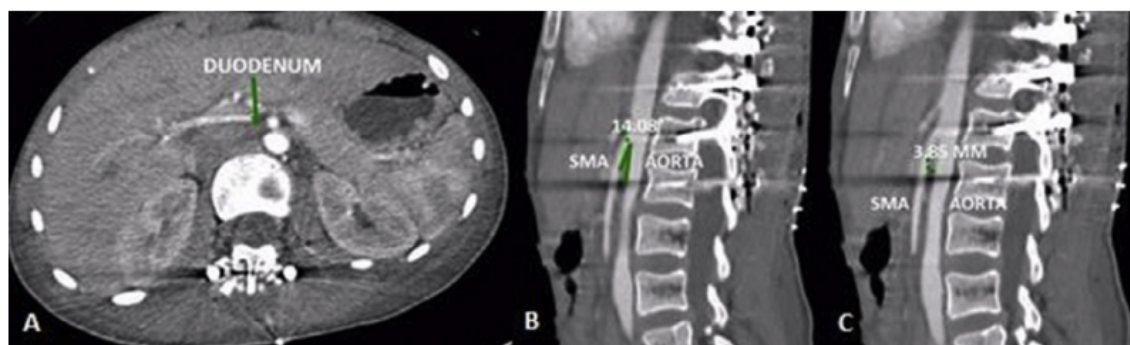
Abdominal CT angiography: A) Duodenal impingement. B) Aortomesenteric angle of 14°. C) Aortomesenteric diameter of 3.8 mm.
